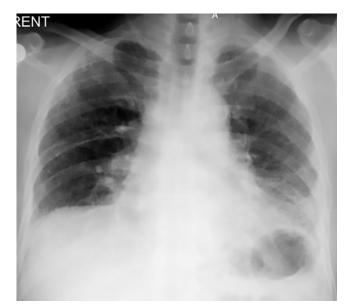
Admission Posteroanterior Chest Radiography
